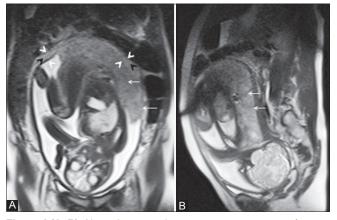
(A, B): Normal mature placenta at upper segment of uterus at 37 weeks of gestation. (A, B) Coronal and sagittal T2 HASTE MR images show a mildly heterogeneous placenta with normal placental septi (white arrows) and triple-layered appearance of normal myometrium (white and black arrowheads)
